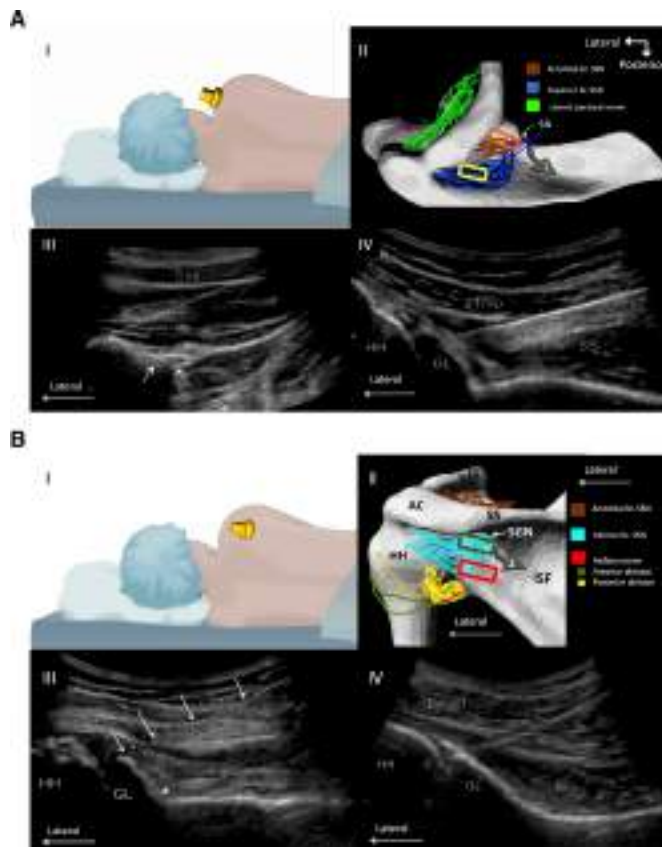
Targets for suprascapular nerve at supraspinatus and infraspinatus fossa. (A) At the supraspinatus fossa. I. The position of the patient and the curvilinear probe in the supraspinatus fossa. II. The distribution of articular branches of the suprascapular nerve (SSN) in superior scapula adapted from Tran *et al.*⁸ The positions of the ultrasound probe are also shown here. The orange and yellow rectangles represented the position where the ultrasound images in III and IV were taken, respectively. Gray arrow indicates the course of the motor branch to the supraspinatus. III. Ultrasound image at scapular notch. The target for acromial branch is marked with X and the notch is marked with arrows. IV. Ultrasound image at the suprascapular fossa. The target of the superior branch of the suprascapular nerve is the anterosuperior glenoid. (B) At the infraspinatus fossa. I. The position of the patient and the curvilinear probe in the infraspinatus fossa. II. The distribution of articular branches to the shoulder in posterior scapula adapted from Tran *et al.*⁸ The positions of ultrasound probe are also shown here. The green and red rectangles represented the position where the ultrasound images in III and IV were taken, respectively. The gray arrow indicates the motor branch to the infraspinatus. III. Ultrasound image at superoposterior glenoid. At this position, the spinoglenoid notch (*) is seen on the medial aspect of the GL. The needle is indicated by the arrows. IV. Ultrasound image at the inferoposterior glenoid. At this site, the scapula on the medial aspect of the glenoid is smooth. GL, glenoid; HH, humeral head; IS, infraspinatus; SS, supraspinatus; Trap, trapezius; SN, scapular notch. Reproduced with courtesy of Philip Peng Educational Series and Dr. Agnes Stogicza.
